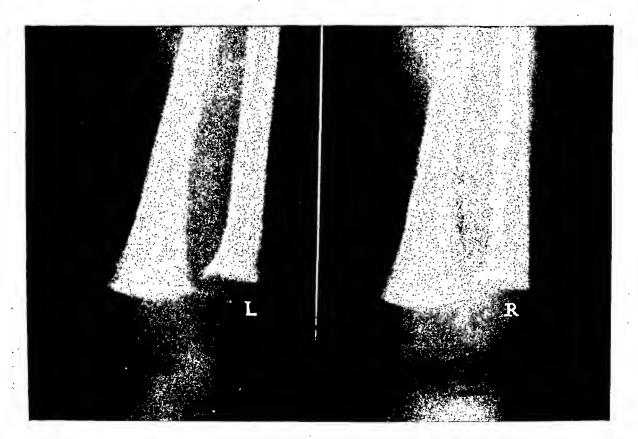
"Cupping" and "spurring" seen in the roentgenogram of right ulna but almost unnoticeable on the roentgenogram of the left ulna of a three month old baby, taken at the same time but with slightly different angle.
